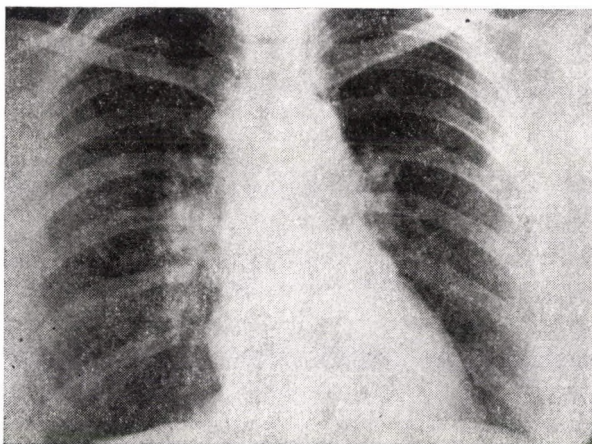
Chest X-ray one year after the beginning of the therapy
